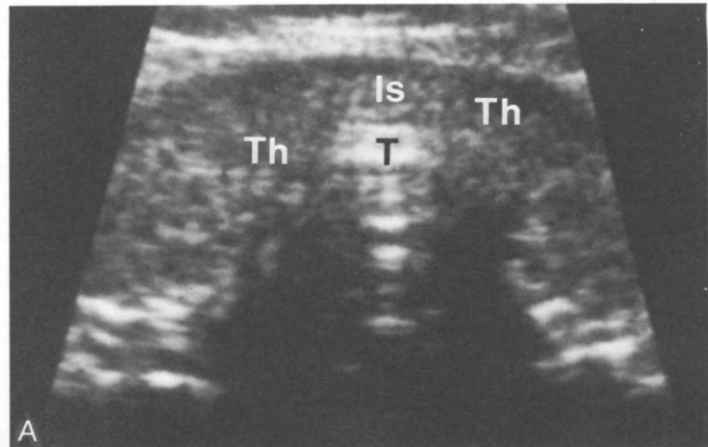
Transverse ultrasound scans. *A*, Normal thyroid gland. *B*, A right lobe focal echogenic nodule (Is = isthmus; N = nodule; T = trachea; Th = thyroid; and LCA and RCA = left and right carotid arteries).
